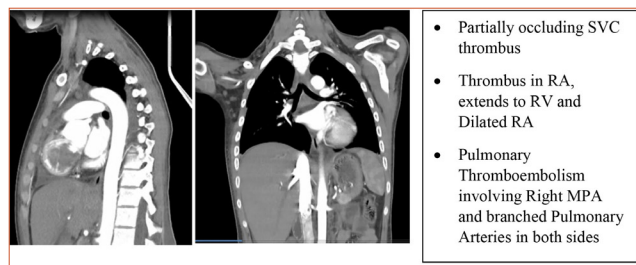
CT Stills of Thorax
